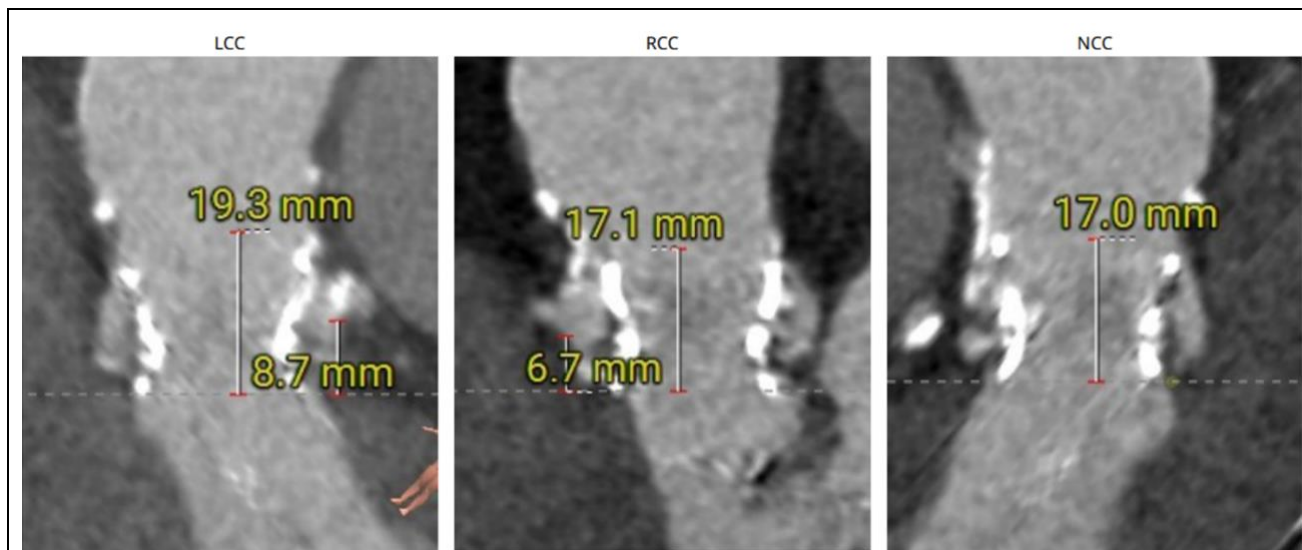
CT-derived sinus height measurements used for Evolut FX+ 23 mm sizing and deployment depth planning. Sinus heights shown left to right: LCC (left coronary cusp), RCC (right coronary cusp), NCC (non-coronary cusp). The virtual sizing confirmed sufficient sinus dimensions to accommodate the third valve frame without coronary compromise, supporting the selection of a supra-annular self-expanding device over a balloon-expandable alternative.
